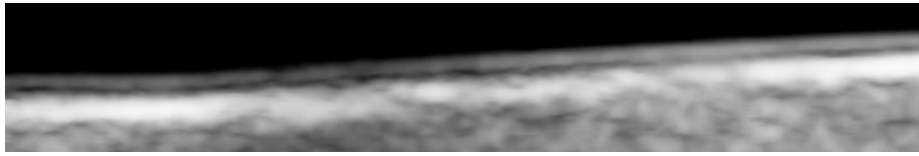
ROI for the ultrasound image in Fig. 1.
